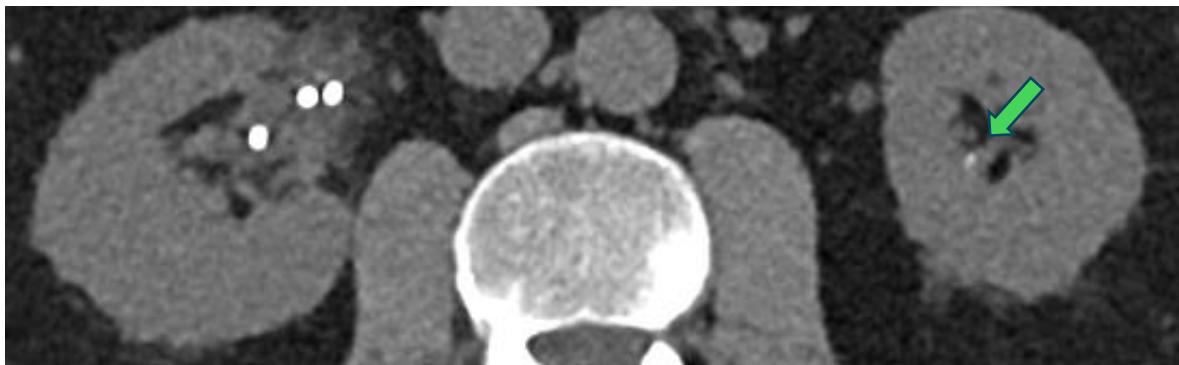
CT scan of March 2024 shows a 4mm left kidney stone that is indicated with a green arrow.
